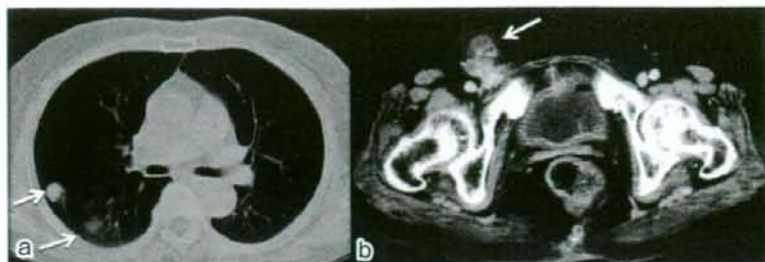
(a) Computed tomography (CT) of the chest on admission shows two nodular shadows in the right lung field. (b) Abdominal CT on admission shows the enlargement of right inguinal and abdominal lymph nodes. The arrow shows the swelling of the former.
